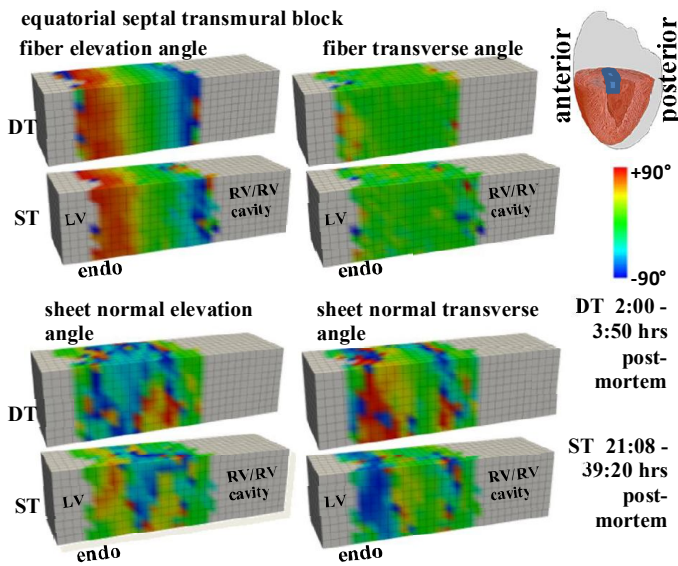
Myocardial structural orientations in the mid-equatorial septal block, imaged in scan 1 (see Table I). DT - DT-MRI, ST - Structure Tensor analysis of HR-MRI.
